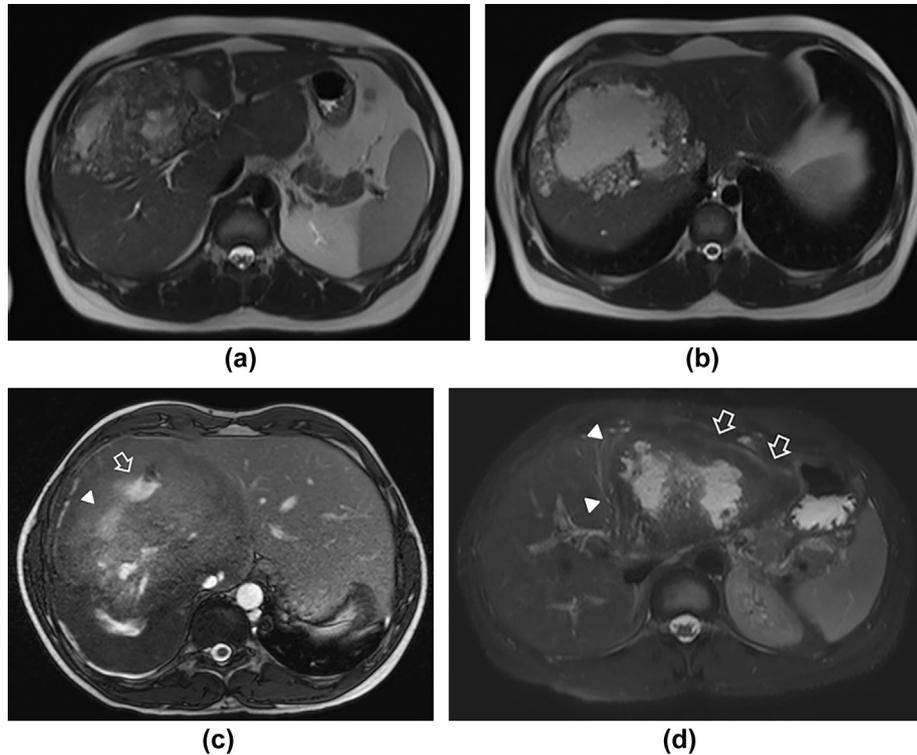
T2-weighted MRI in the evaluation of morphological and liquefactive components of AE lesions: (a) a sizeable complex of multiple small irregular cystic lesions are seen in a transitional stage with additional early irregular central cystic components. (b) A Kodama type 3 lesion demonstrating a central cystic component with a rind of solid tissue containing multiple small peripheral vesicles. (c) A mature Kodama type 3 lesion with more well-demarcated margins with liquefactive (white arrow, central high T2 signal) and more solid coagulative (white triangle, central intermediate T2 signal) internal necrosis. The image also demonstrates caval compromise with direct trans-diaphragmatic extension towards the right lung base and a small volume right pleural effusion. (d) Fat-suppressed T2-weighted imaging demonstrates some peripheral high hepatic parenchymal T2 signal along the anterior (white arrow) and medial margin (white triangle) of the left hepatic lesion, thought to represent high perilesional oedema. Note the presence of low T2 signal at the lesion margin thought to represent fibrotic tissue in (c) and (d).
